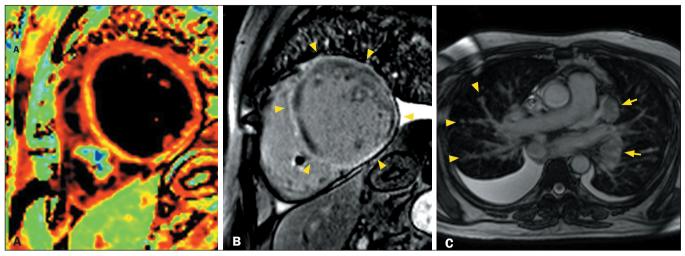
CMR, performed after the implantation of a pacemaker, showing severe LV dilatation, systolic dysfunction, and myocardial edema (A), with a prolonged T2 relaxation time (72 ms), together with circumferential ring-like LGE in the basal and middle segments (arrowheads in B), in a 48-year-old man with a biopsy-proven cardiac involvement in sarcoidosis who presented with total atrioventricular block. Axial magnetic resonance imaging scan of the chest, showing peribronchovas-cular interface irregularity (arrowheads in C), mediastinal lymph node enlargement (arrows in C), and pleural effusion.
